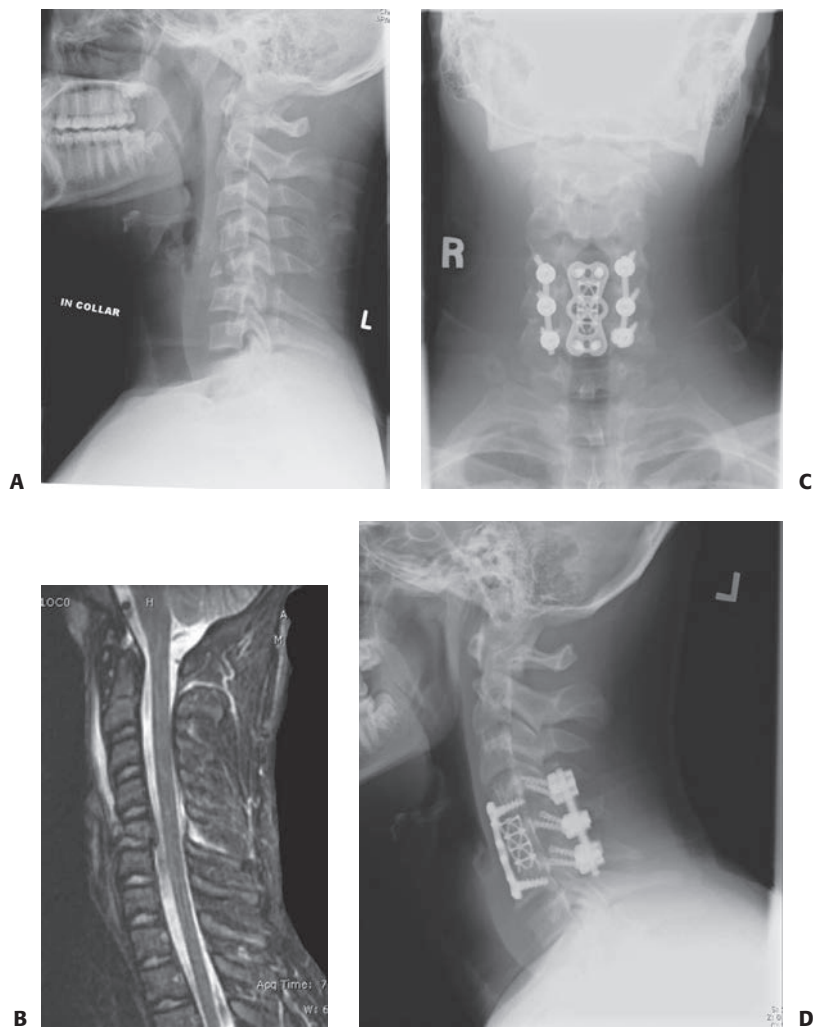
Radiograph (A) and MRI (B) of 12-year-old boy with three-column injury sustained during football game. C, D: After anterior and posterior fusion and fixation with anterior plate and screws and posterior instrumentation.
